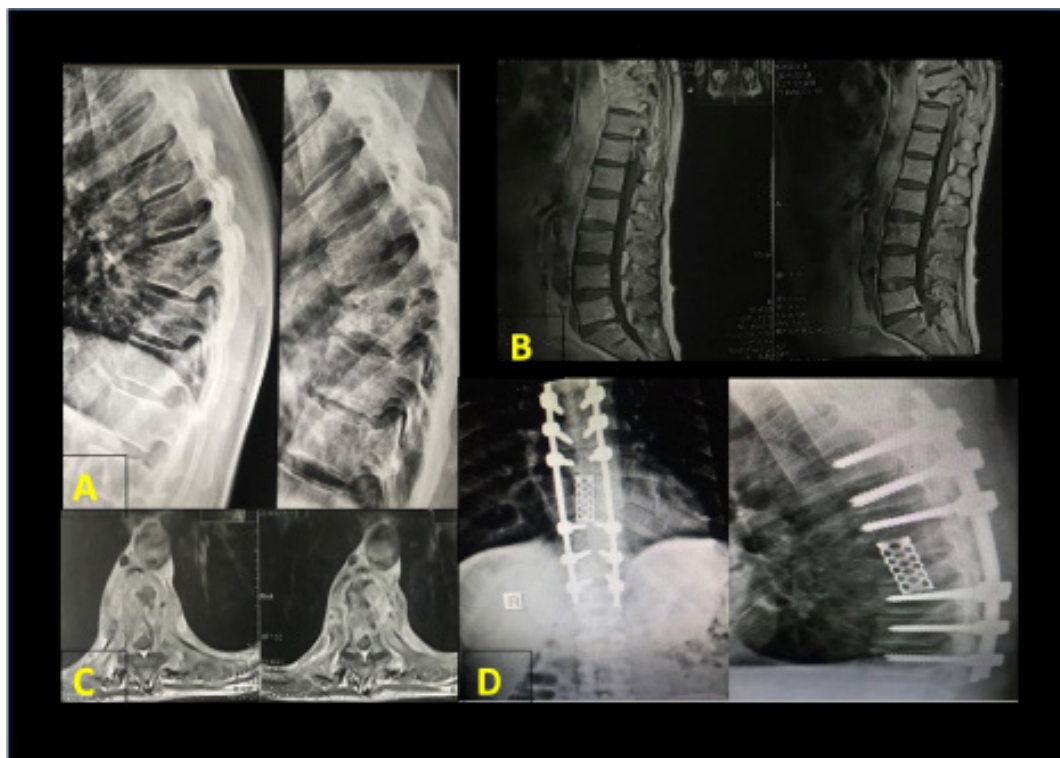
Case 1 Preoperative and postoperative imaging. (A): Preoperative Xray showing the kyphosis at D8-9, (B & C): Sagittal and axial thoracolumbar MRI showing the lesion. (D): Postoperative X-ray showing fixation of D6-8, D11-L1 and insertion of mesh cage.
